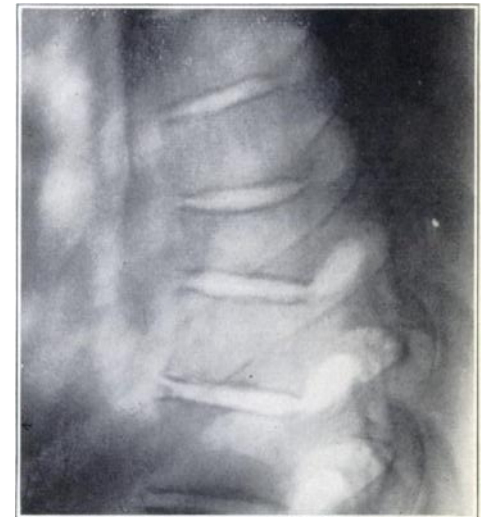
X-ray of epileptic, Case No. 115. Major fracture—D6. Minor fracture—D5.
